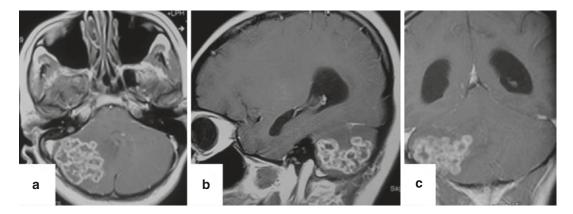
Contrast MRI of the brain; (a) axial, (b) sagittal, and (c) coronal images showing right cerebellar hemispheric large TB lesion (multiple coalescing rings)
